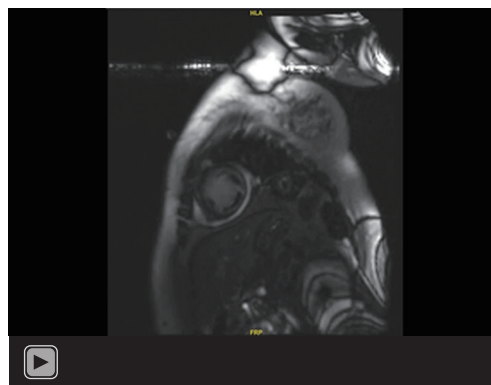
Serial multi-modality imaging of the patient's thrombus, cardiac structure, and function. (A,B) Echocardiography shows the thrombus on the ventricular surface of the posterior lobe of mitral valve, and mitral regurgitation; (C,D) cardiac MRI shows low signal intensity in left ventricle, interventricular septum and the ventricular side of posterior mitral valve leaflet. It also shows diffuse endocardium and subendocardial late gadolinium enhancement in the left ventricle; (E) ^{68}Ga -DOTATATE PET shows diffuse macrophage infiltration, SUVmax 1.9; (F) FAPI PET shows significant fibroblast activation in the left ventricle, SUVmax 5.2; (G,H) reexamination of echocardiography shows the disappearance of cardiac thrombus and the improvement of mitral regurgitation; (I,J) cardiac MRI shows the disappearance of cardiac thrombus and the improvement of late gadolinium enhancement. MRI, magnetic resonance imaging; ^{68}Ga -DOTATATE PET, ^{68}Ga -tetraazacyclododecanetetraacetic acid-DPhe1-Tyr3-octreotate positron emission tomography; SUVmax, maximum standard uptake value; FAPI PET, ^{68}Ga -fibroblast activation protein inhibitor positron emission tomography.
